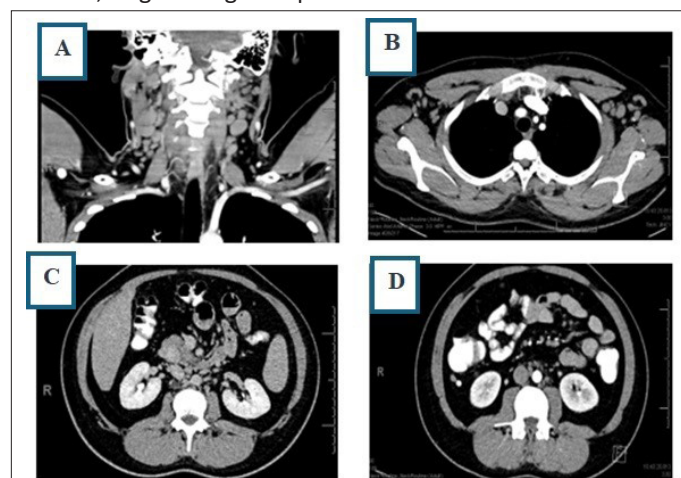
Contrast-enhanced CT imaging demonstrating extensive lymphadenopathy. (A) Coronal view of the neck and upper chest showing cervical lymphadenopathy. (B) Axial chest CT demonstrating bilateral axillary and mediastinal lymph nodes. (C) Axial abdominal CT showing mesenteric lymphadenopathy. (D) Axial abdominal CT demonstrating retroperitoneal lymphadenopathy.
